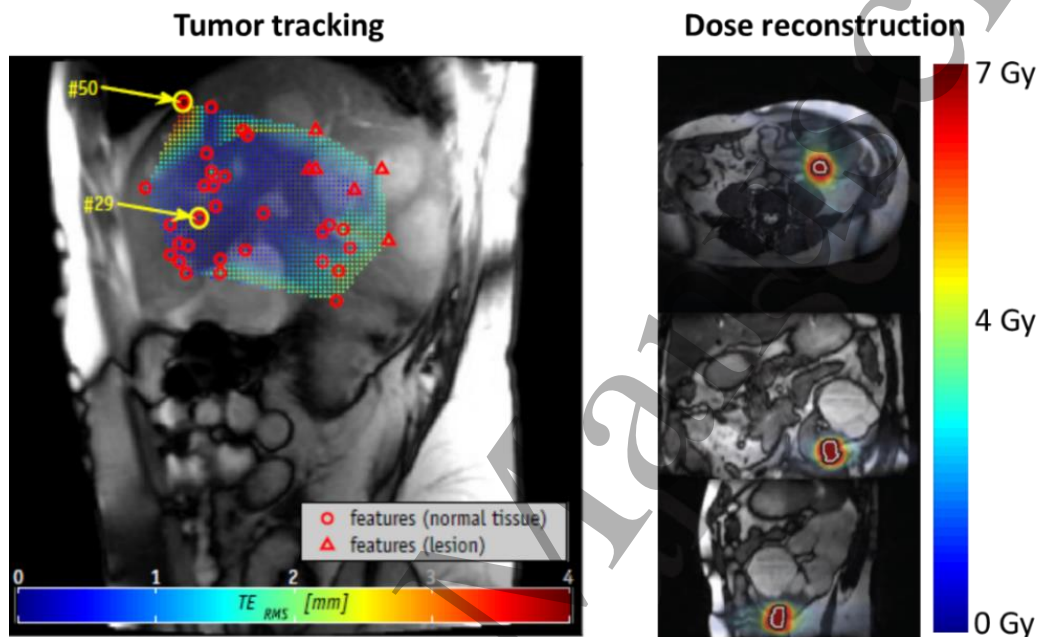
Time-resolved MRI in treatment delivery. An example of tumour tracking approach by means of anatomical landmarks on the left [reprinted with permission from (Paganelli et al. 2015b)]. Dose reconstruction by means of a global motion model strategy [reprinted with permission from (Stemkens et al. 2017)].
